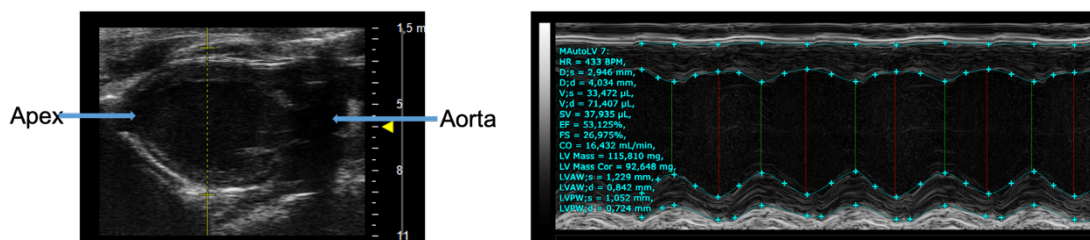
The view of Parasternal Long Axis (PLAX) and measurement of ejection fraction(EF).
